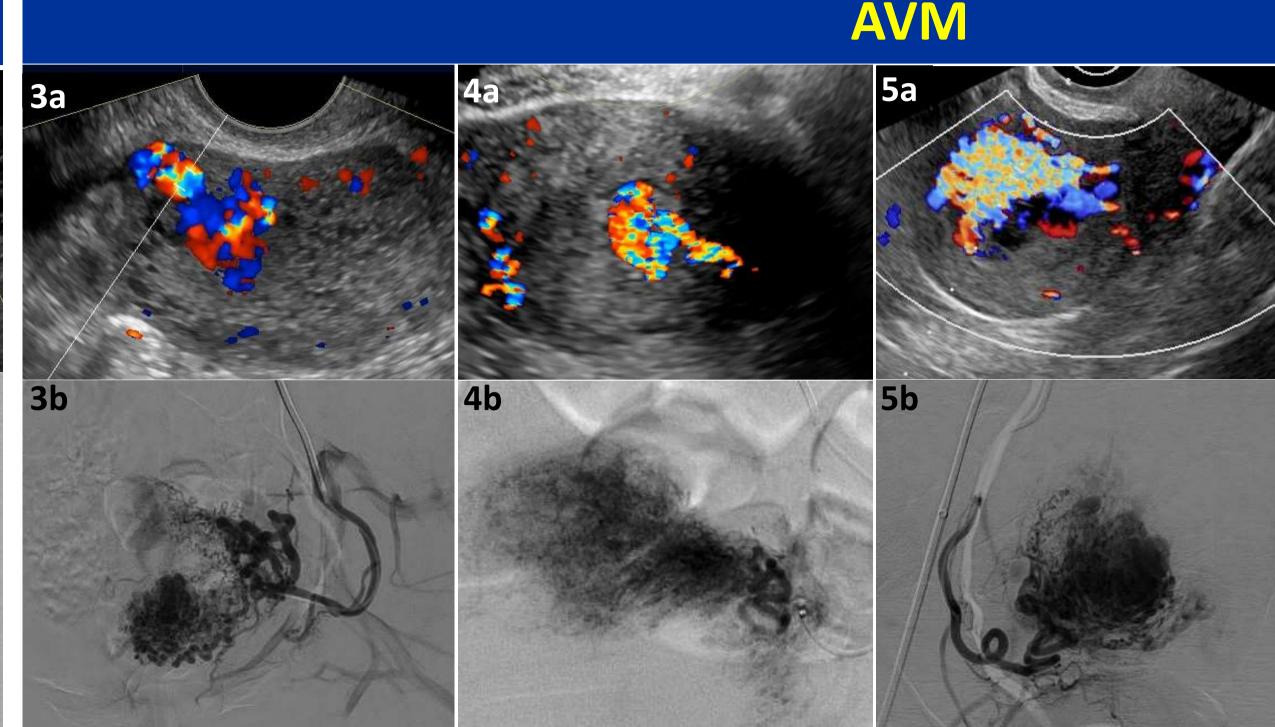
Three selected cases of secondary post-partum hemorrhage refractory to conservative management with a hypervascular myometrial focus on ultrasound (3a-5a). UAE of these lesions demonstrated a hypervascular focus and hypertrophied and/or torturous uterine artery (3b-5b). Early draining vein confirms the diagnosis of AVM on angiography. These cases were embolized either by gelatin foam, microparticles or combination.
